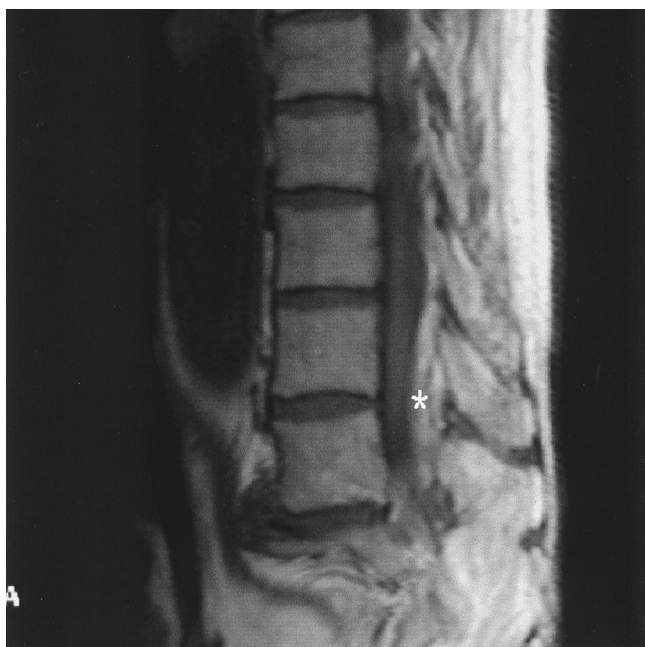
Magnetic resonance imaging study of the lumbar spine 3 days after removal of an epidural catheter. The epidural mass (*) is smaller but still present.
